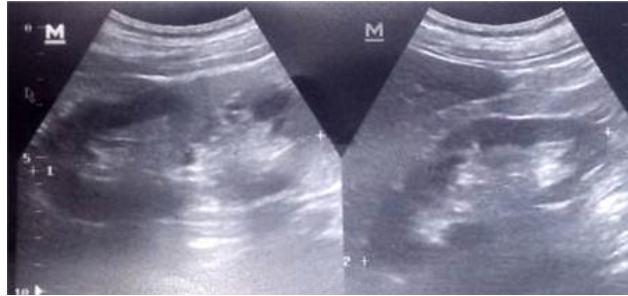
a sonogram reveals normal sonographic appearance of a transplanted kidney in a 34-year old male
